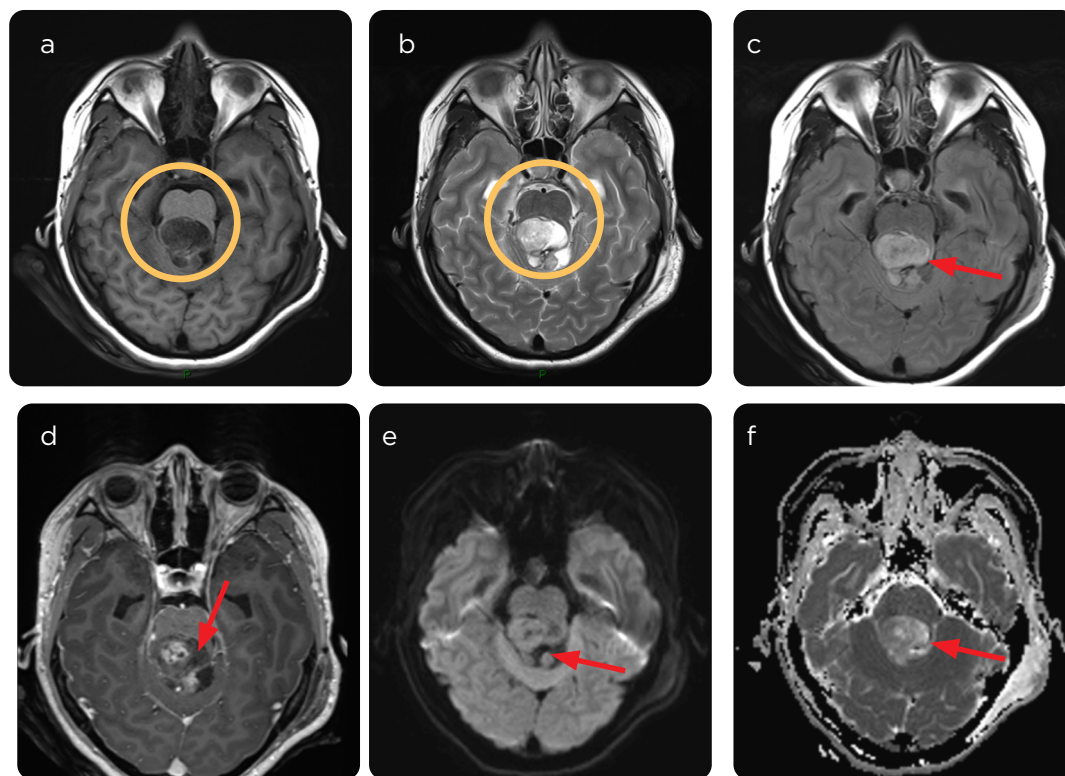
Medulloblastoma. a) MRI with T1 information: low signal. b) Spin echo sequence and c) FLAIR with T2 information: high signal. d) With contrast medium: heterogeneous enhancement. e and f) Diffusion sequences and ADC map: some areas with water diffusion restriction.
